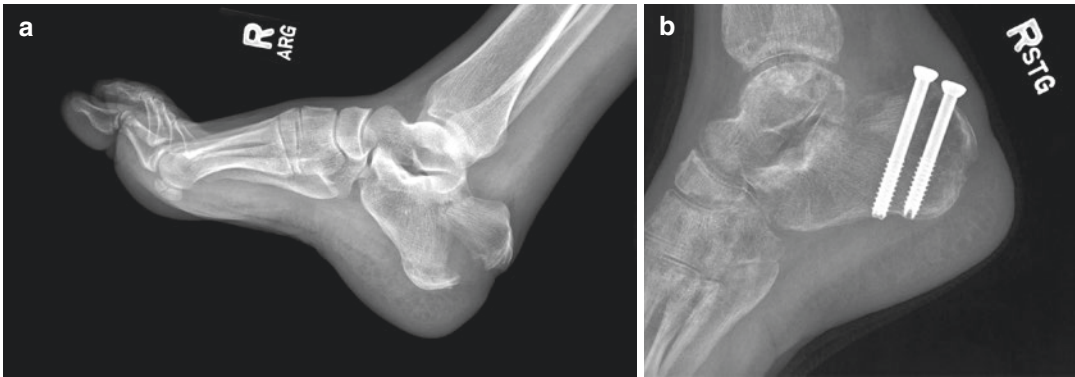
Example of a closed, extra-articular calcaneal tuberosity fracture requiring urgent treatment. (a) Lateral radiographs of the foot and ankle preoperatively and (b)
